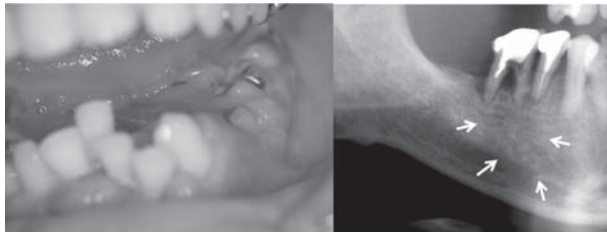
BRONJ symptoms in stage 0 patients. Left photo: Intra-oral view of an acute dental infection case (Case 2). Diffuse swelling and a discharge of pus were observed in the 43–36 area without bone exposure. Right radiograph: Osteosclerotic and lytic findings were observed (arrow) in the 46 and 45 areas (Case 3).
